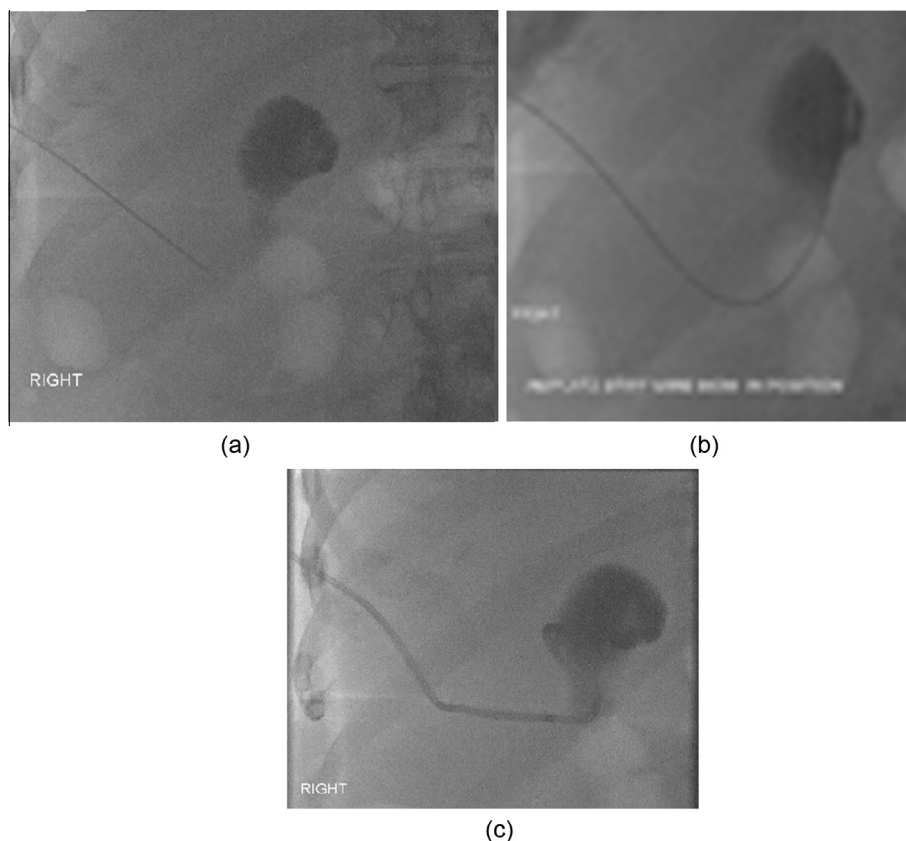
65 years old female patient with GBP type II with sub-hepatic collection. Needle was inserted through the liver parenchyma to the collection guided by Ultrasound. Needle position was confirmed by contrast injection under fluoroscopy (a) and then 0.35 super stiff Amplatz guide wire was inserted in the collection (b). The needle was removed and catheter was inserted over the guide wire supported by its plastic stiffener. The catheter was advanced to the collection and then stiffener and guide wire were removed and self-retaining loop of the catheter was formed confirmed by contrast injection(c).
